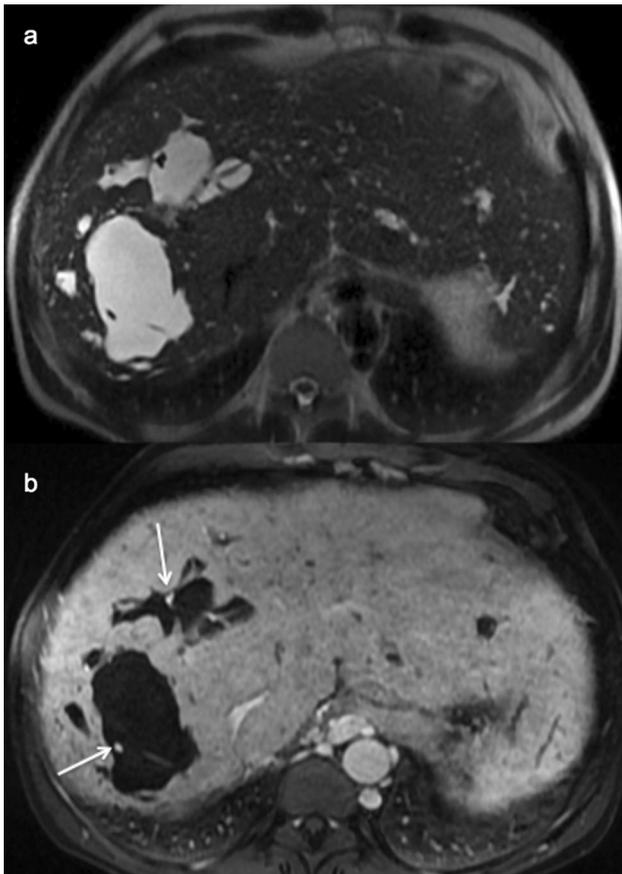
Caroli disease. Axial T2-w (a) and contrast-enhanced T1-w (b) MR images show saccular cystic dilatations of the intrahepatic bile ducts associated with “central dot sign” (white arrows)
